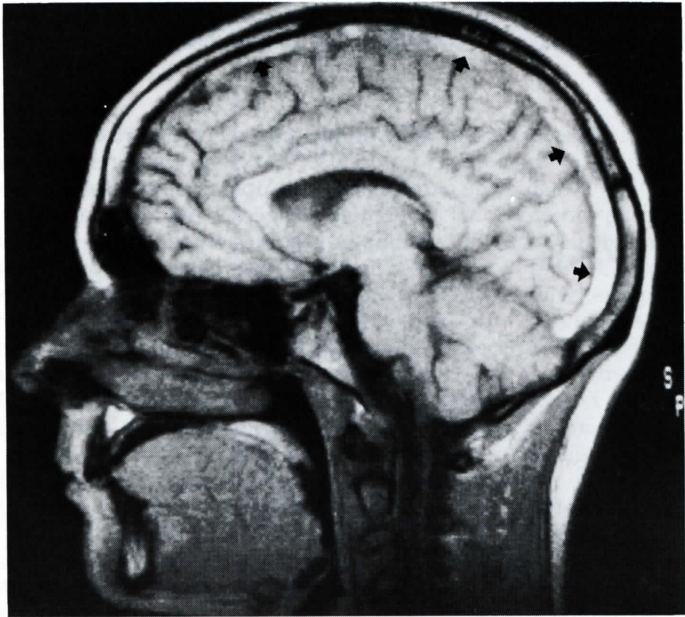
MRI scan of T1-weighted hypersignal indicating SSS thrombosis (*arrows*).
